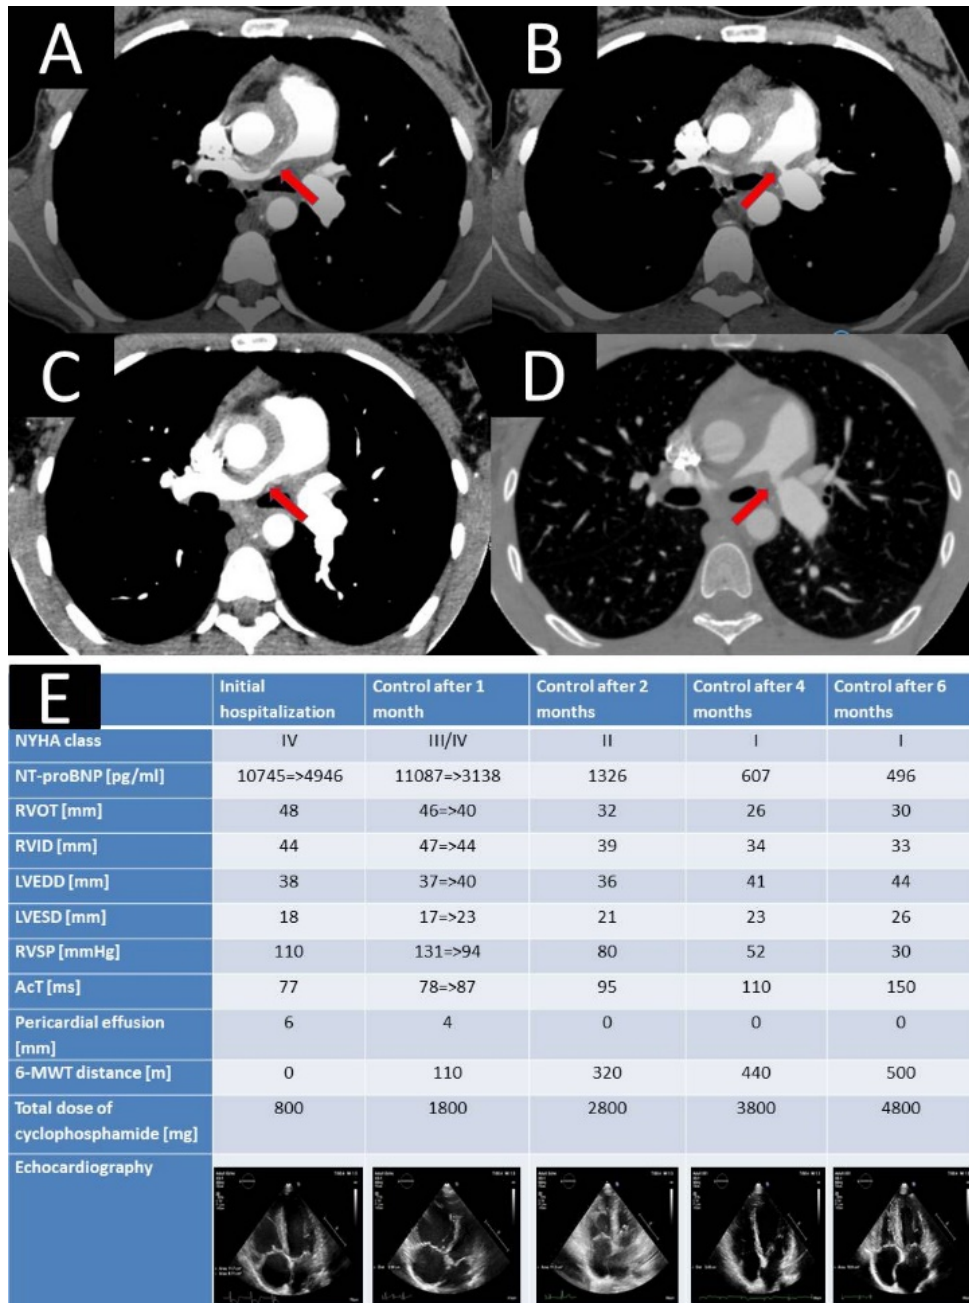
Computed tomography with contrast. A. The initial angio-CT scan showed critical stenosis in pulmonary arteries, causing 99% narrowing of the lumen of RPA. B. 95% of the LPA. C. Control angio-CT scan after six months showed substantial regression of stenosis in both RPA; D. and LPA. E. Clinical, laboratory and echocardiography parameters according to the total dose of cyclophosphamide in subsequent hospitalizations.
